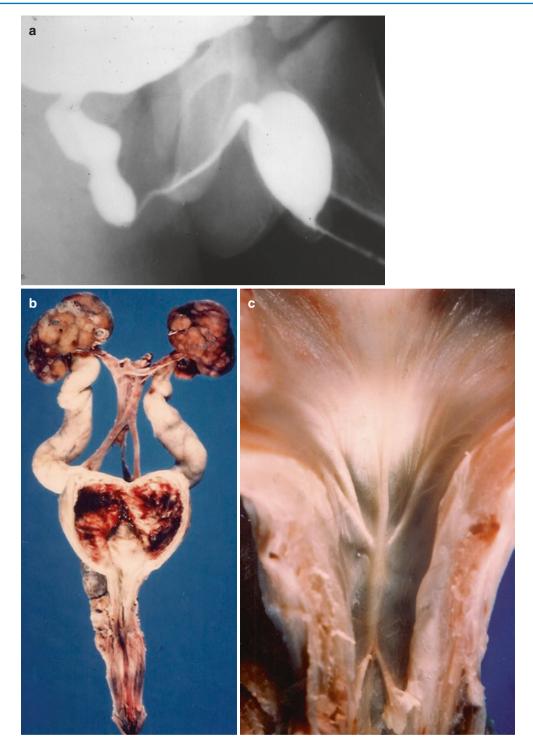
(a) Posterior urethral valves x-ray with contrast. (b) Pathology of PUV. (c) Pathology close-up of the valves
